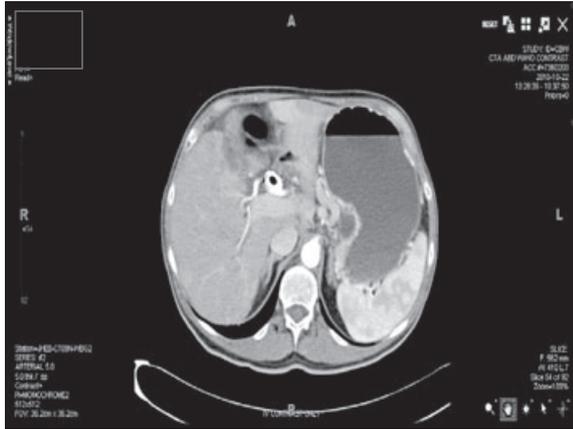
Abdominal CT scan of 64 year-old male showing normal liver.
